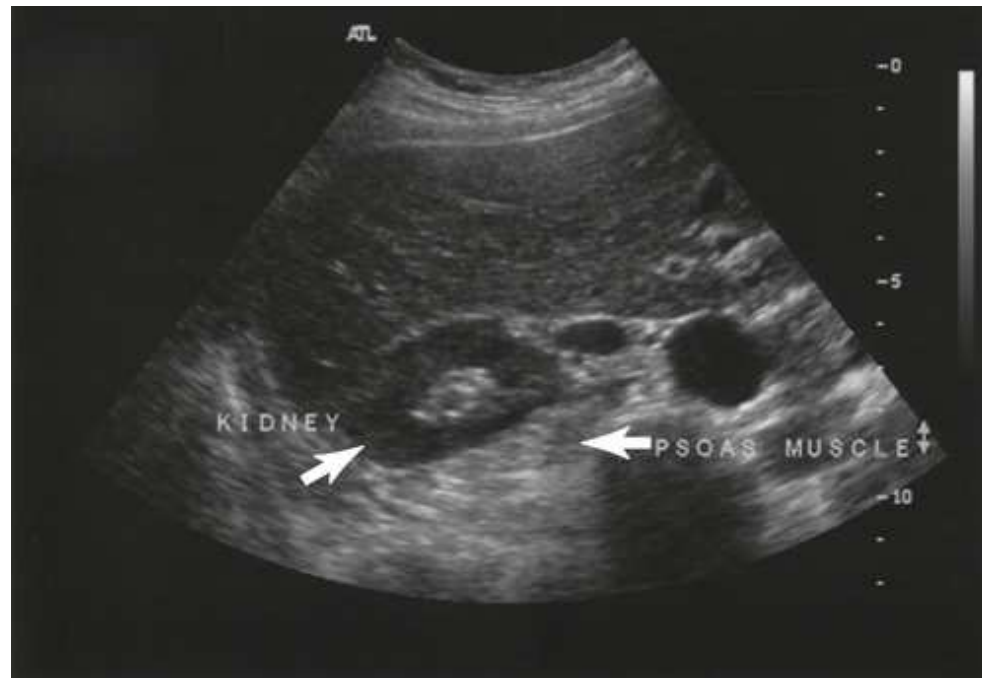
Transverse sonogram of right kidney lying posterior to the liver and lateral to the psoas muscle.
